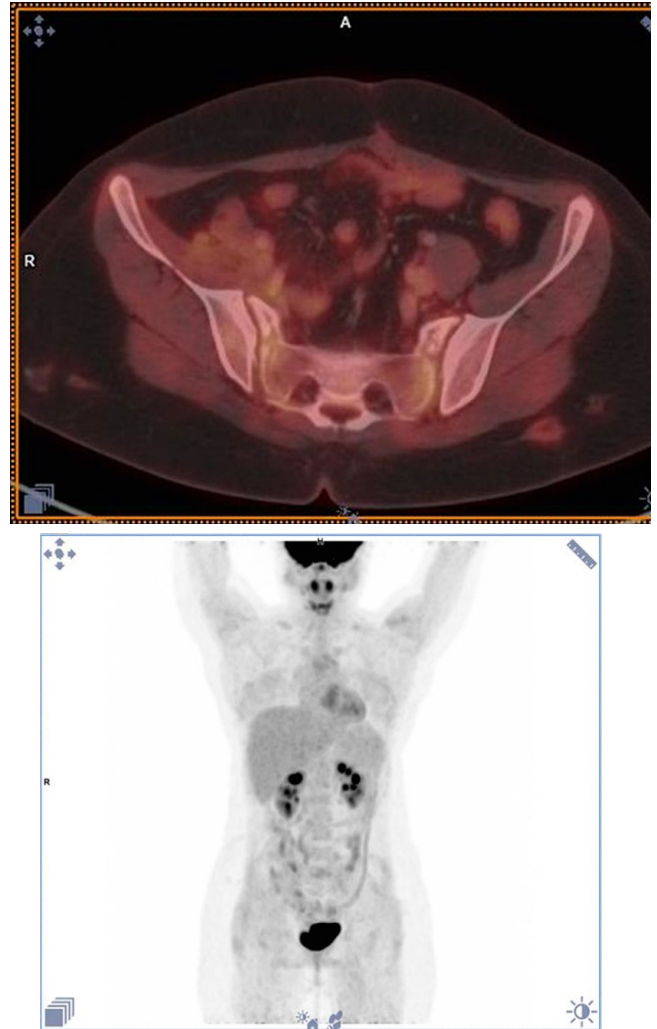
PET-CT scan after 3<sup>rd</sup>-line therapy in ALCL patient. Black arrow demonstrates diffuse thickening of right iliac muscle with local metabolic activity
